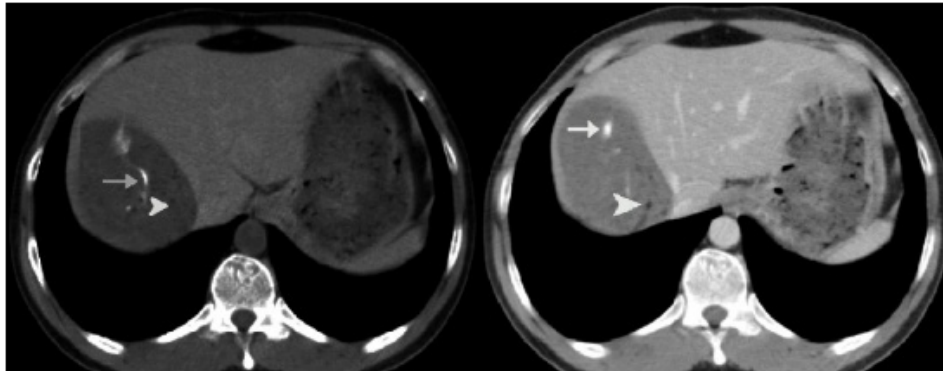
Axial CT images without contrast (a) and with contrast agent (b), show a well-circumscribed cystic lesion in the right lobe of the liver, measuring approximately 10 X 8 cm, with globules of hypodense fat attenuation foci within (arrowhead) and internal calcifications (arrow). The biliary tree appeared to be regular (no dilatation seen).
